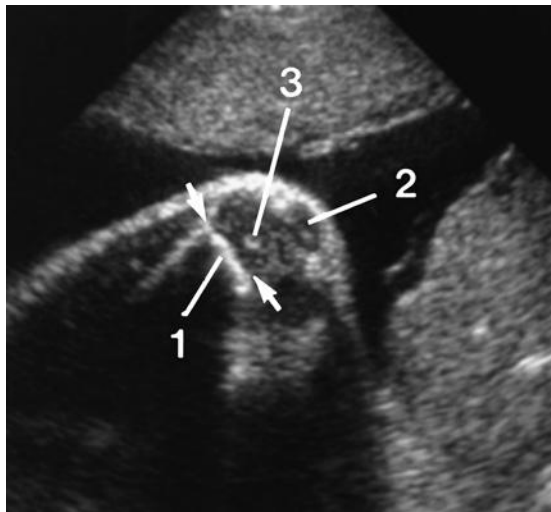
Sector sonogram of the distal femur taken such that the lines of sight from the transducer intersect the inferior end of the femoral metaphysis at the epiphyseal plate (1). By this maneuver, the full thickness of the distal ossified femur is seen sonographically (compare with Fig. 8-24). Now, the thickness of the epiphysis (arrows) and ossified femoral shaft match perfectly. 2, patella; 3, secondary ossification center of the distal femoral epiphysis.
